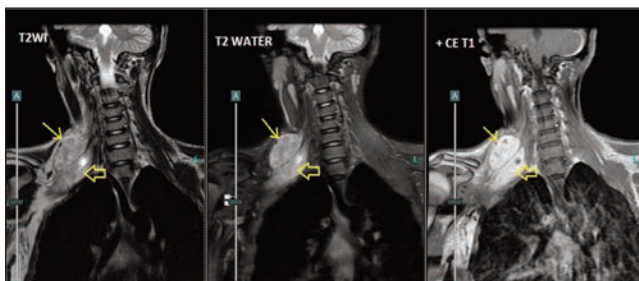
Coronal MR images showing two large ovoid schwannomas in right supraclavicular fossa. Note the long axis of the lesions is parallel to long axis of C4-C5 and C5-C6 nerves. Few tiny areas of necrosis seen in both upper and lower lesions appearing as non-enhancing intralesional foci. No extension into spinal canal seen.
